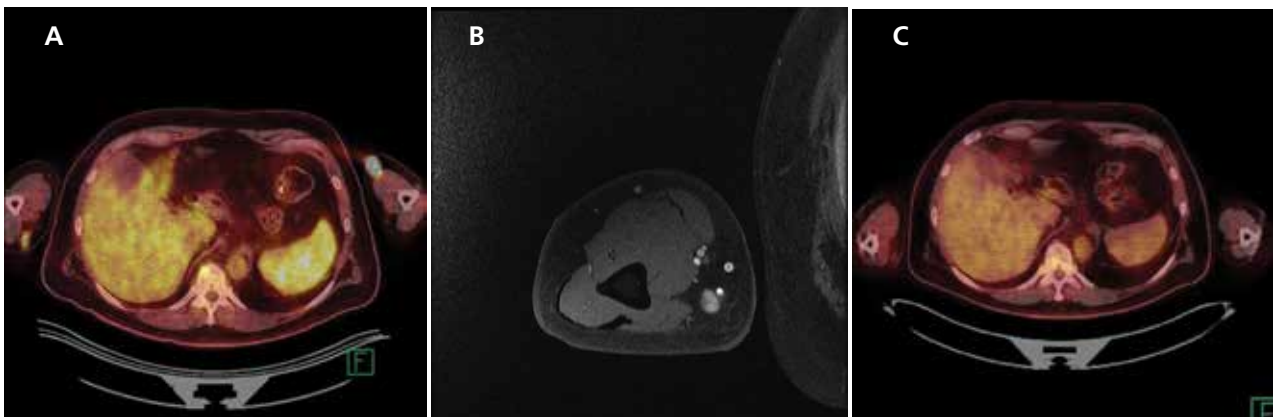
(A) PET/CT scan, (B) MRI of local melanoma recurrence, and (C) resolution of FDG avidity in arm and spleen.
